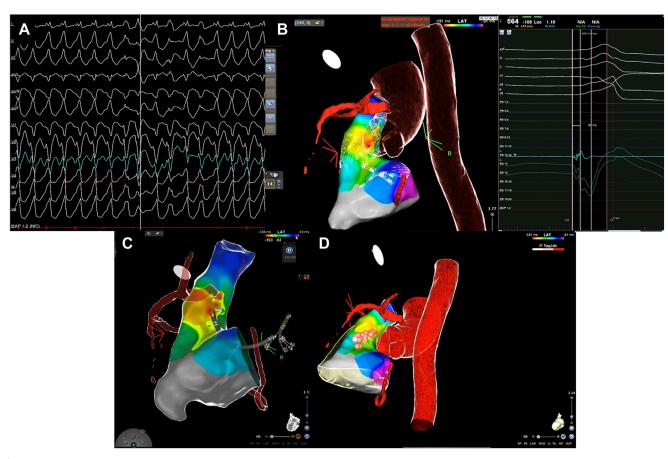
A: VT induction with morphology identical to that objectified in 2018. B: Activation map showing the earliest activation at the posteroseptal aspect of the RVOT (25 ms pre-QRS with a negative deflection [QS morphology] in the unipolar electrogram). B, C: 3D electroanatomic map integrated to the CT coronary angiogram. Notice the relationship between the ablation catheter and the coronary trajectory. D: Ablation points (30W, ablation index of 450) with subsequent disappearance of ventricular extrasystoles. 3D = 3-dimensional; CT = computed tomography; RVOT = right ventricle outflow tract; VT = ventricular tachy-cardia.
